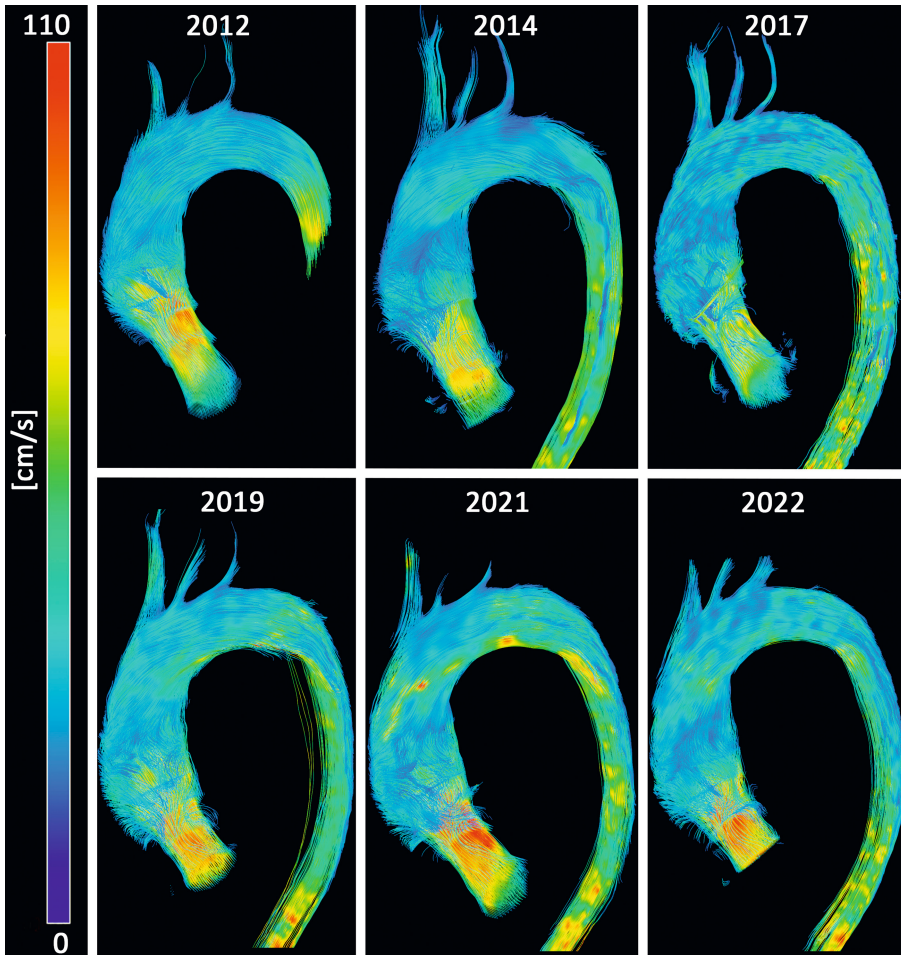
Peak systolic streamline visualizations of the 4D flow MRI acquisitions of a patient with an ascending aortic aneurysm.
